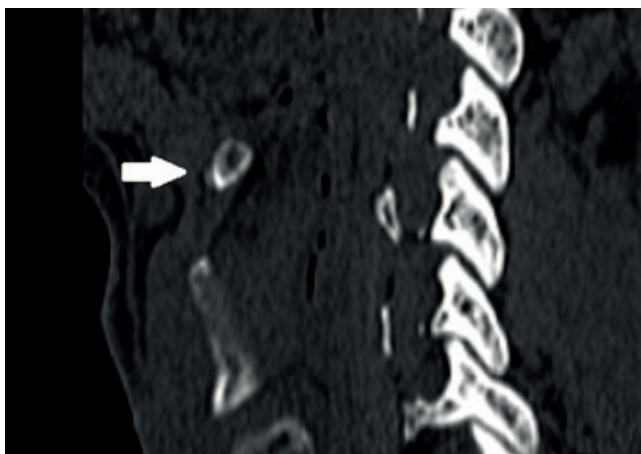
Cervical CT sagittal section; fracture at the juncture of the hyoid bone left corpus major horn
